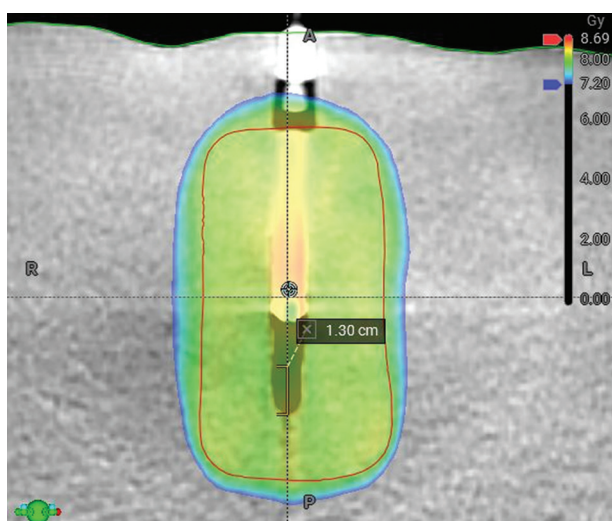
Transversal computed tomography slice of the polymethyl methacrylate insert with the chamber cavity, including dose distribution and reference point
